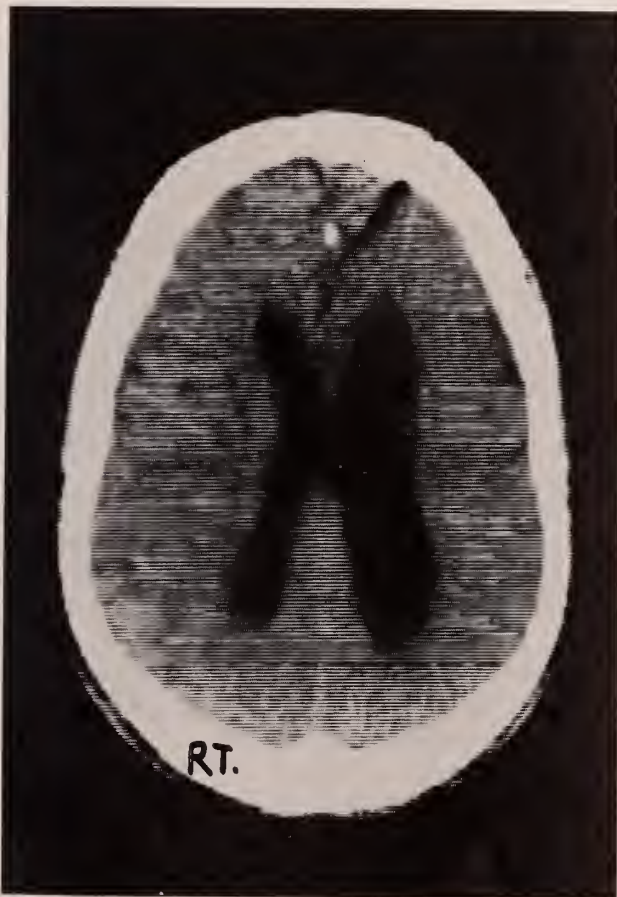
Case 2, pre contrast brain CT scan.
